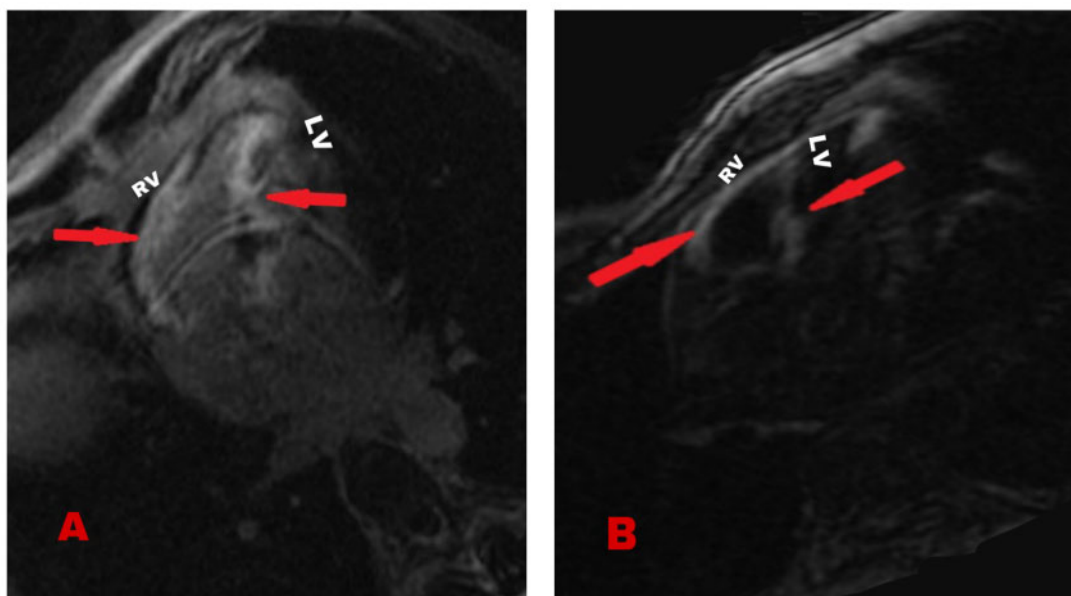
Cardiac magnetic resonance imaging. (A) Four-chamber view and (B) three-chamber view show late gadolinium enhancement in the right ventricular free wall as well as septum. LV, left ventricle; RV, right ventricle.
